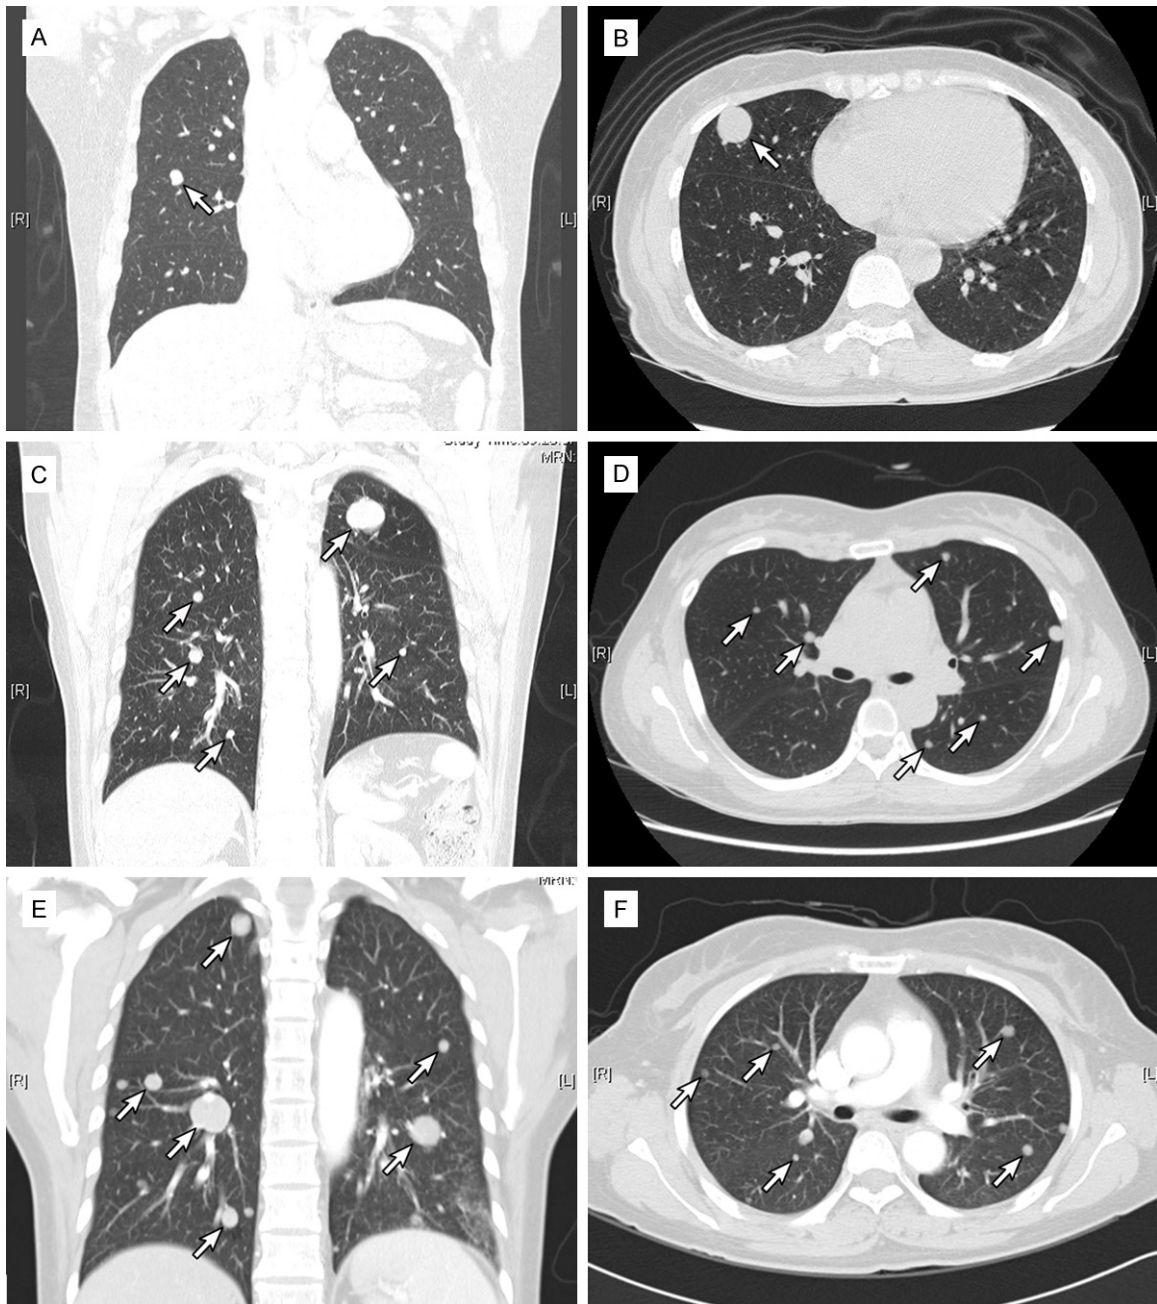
Imaging findings of pulmonary BML. (A) Patient 3. Chest CT reveals a 1.3-cm single, well-circumscribed nodule (white arrow) in the right middle lobe. (B) Patient 1. A 2.0-cm single, spherical nodular lesion (white arrow) is noted in the right middle lobe. (C-F) There are multiple, round, well-circumscribed and variable-sized nodules (white arrows) in both lungs. (C. Patient 5; D. Patient 7; E. Patient 8; F. Patient 10).
